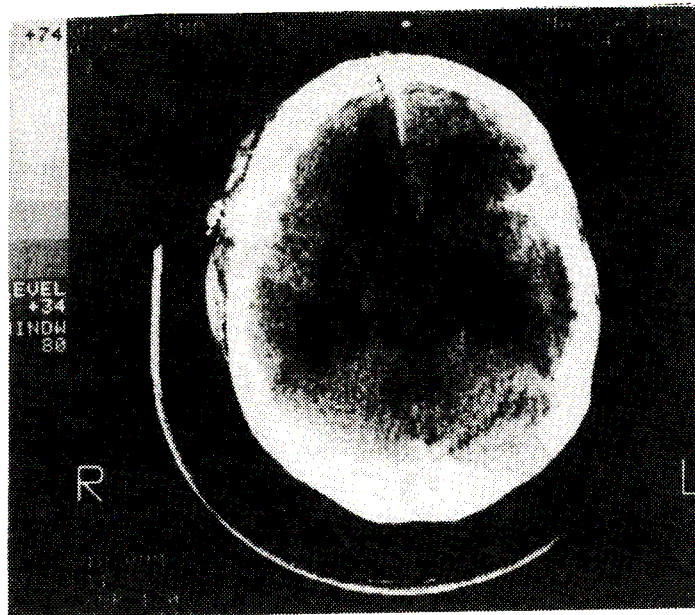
Post-operative CT.
